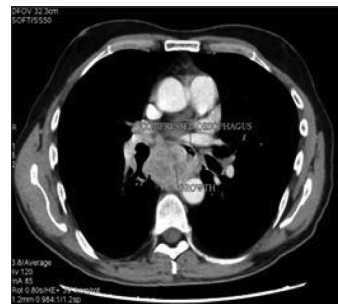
Axial CT image showing mass in relation to esophagus compressing
